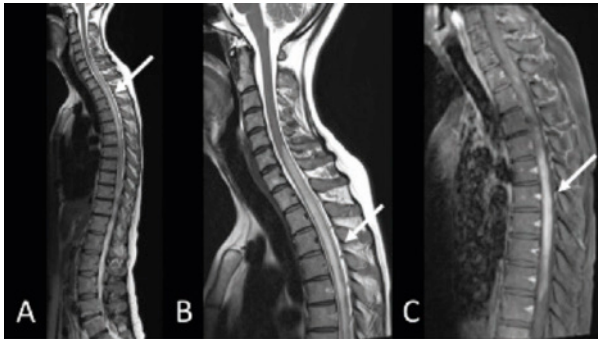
(A) spinal sagittal T2-weighted magnetic resonance image (MRI) demonstrate high signal from C6 to the conus medullaris and (B) cervical sagittal T2-weighted MRI demonstrate longitudinal myelitis in the cervical spine. (C) Post gadolinium T1 sequence with heterogeneous contrast enhancement from Th3 to Th8.
